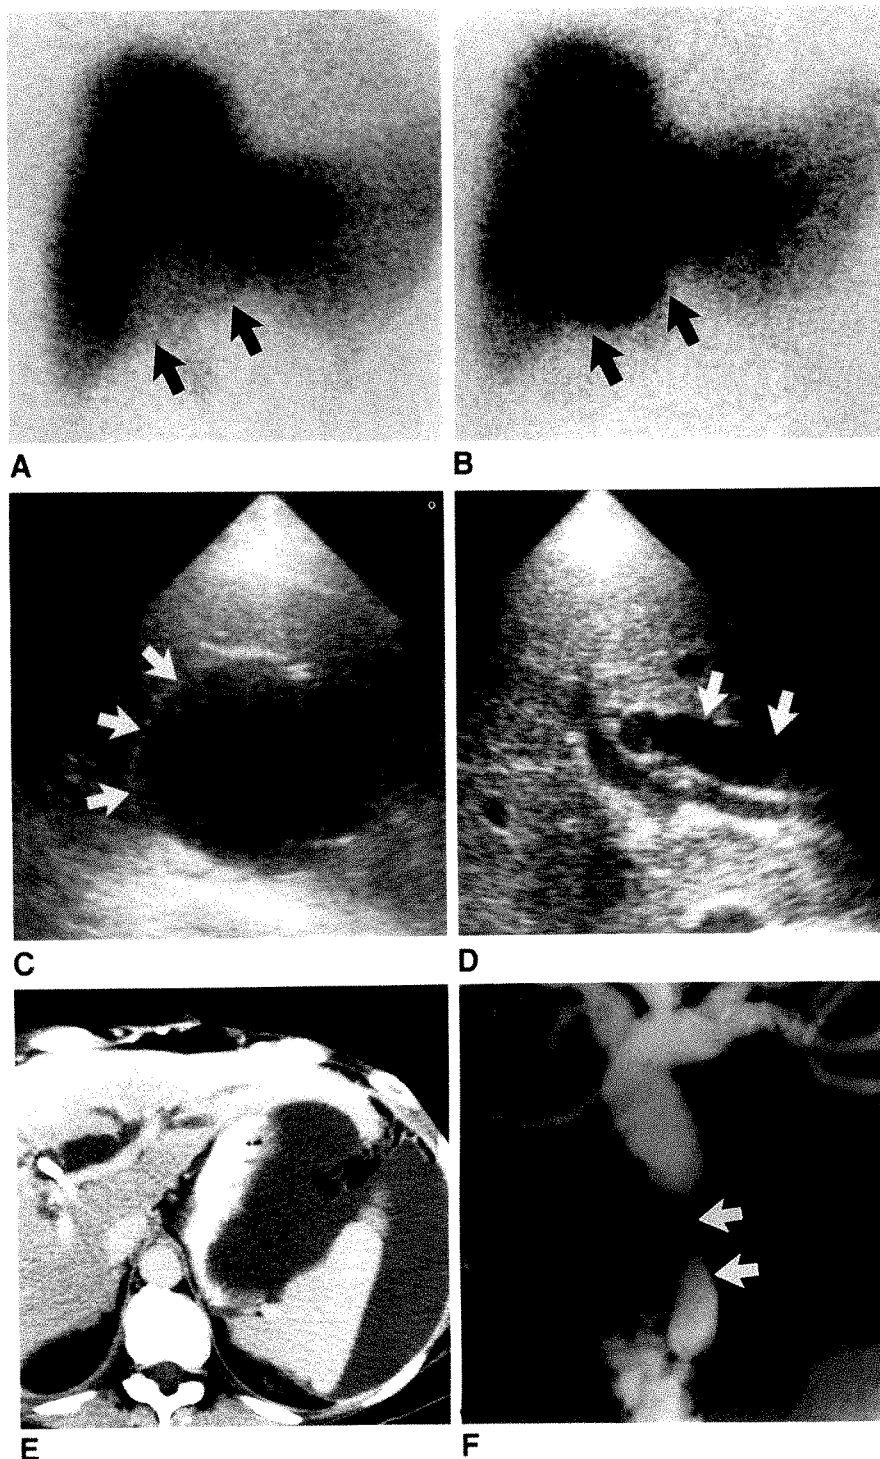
Recurrent cholangiocarcinoma in a 43-year-old woman after choledochocholedochostomy reconstruction. Because of inadvertent T-tube dislodgment, biliary leakage and obstruction exist concomitantly. Signs and symptoms were nonspecific; consequently, hepatobiliary scintigraphy and sonography were performed on same day as screening examinations. However, when there is high suspicion of biliary leak, and when biliary catheter is in place, cholangiography is first diagnostic examination.
